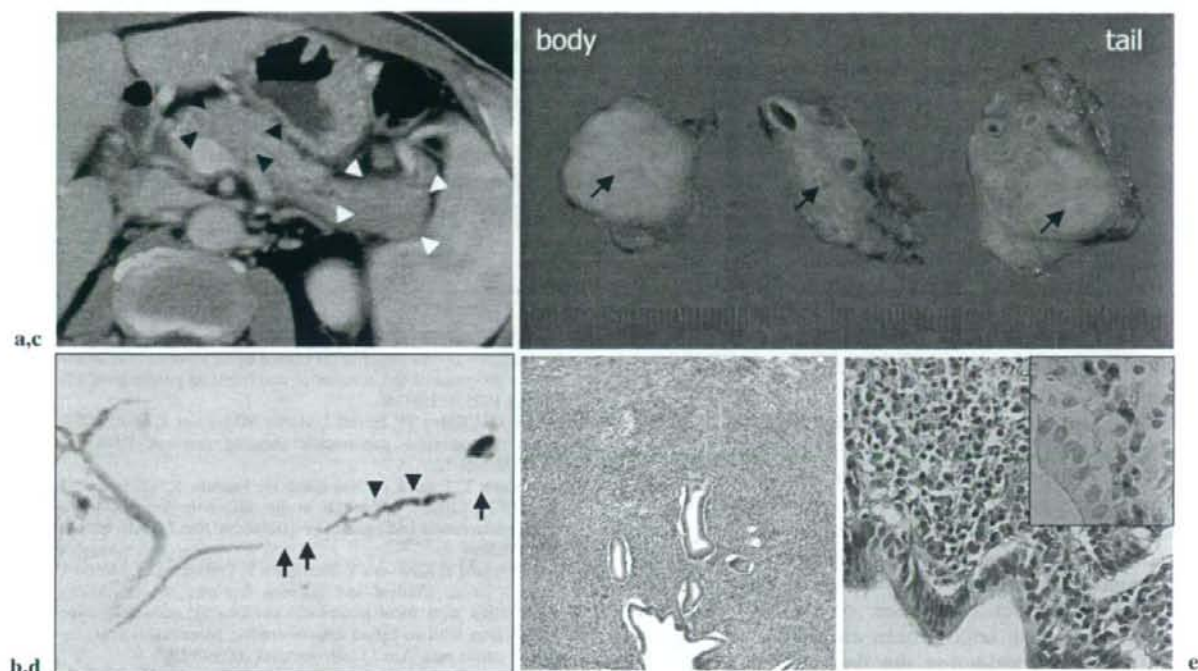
Case 2. a CT showed two lesions, in the body and tail of the pancreas (*arrowheads*), and exhibited subtle delayed enhancement; delayed phase. b MRCP revealed obstruction of the MPD concordant with the tumors (*arrows*), and slight dilatation between the tumors (*arrowheads*). c On macroscopic examination, the cut surface of the tumors showed swelling of the parenchyma, and the border between the tumor and the surrounding pancreatic tissue was unclear. The
